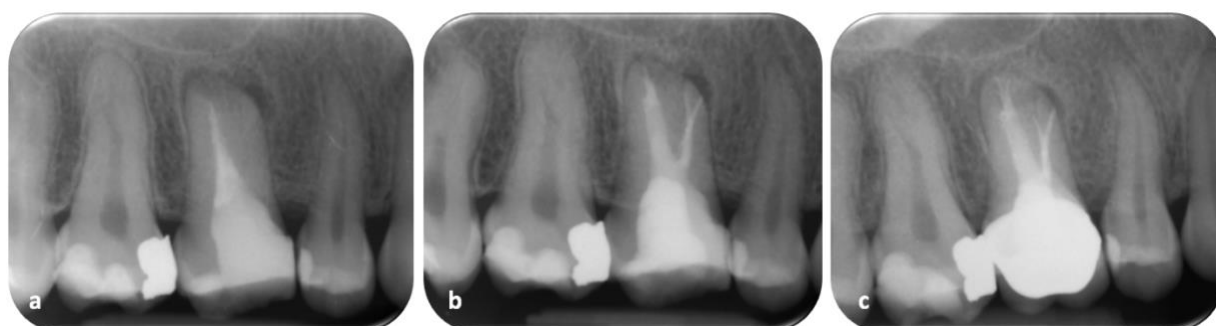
Review of teeth 16, 26 and 27 (a) Pre-operative radiograph (b) Postoperative radiograph (c) 1-year review, showing periapical radiolucency is less dense
